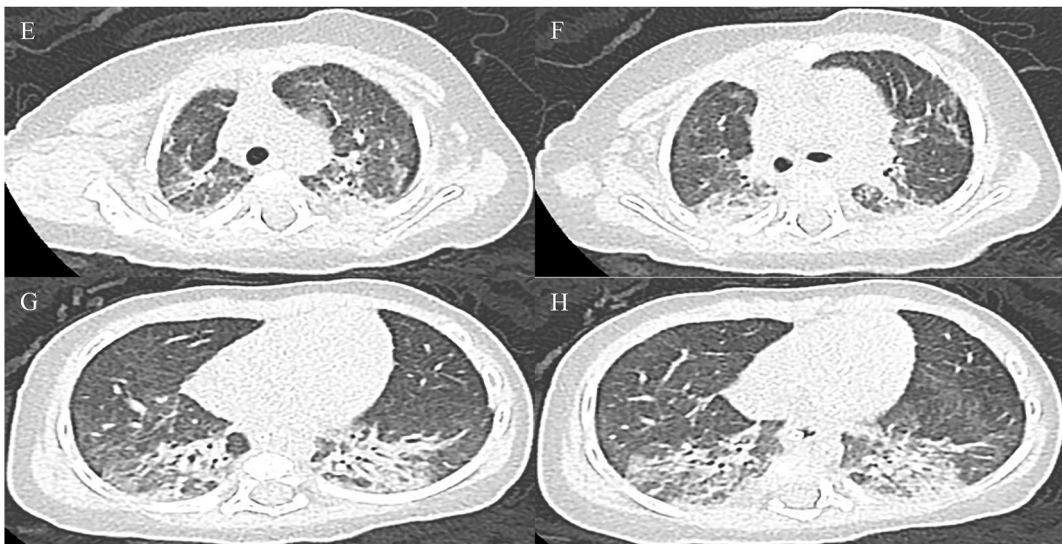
Chest CT after nCoV test turned negative.
